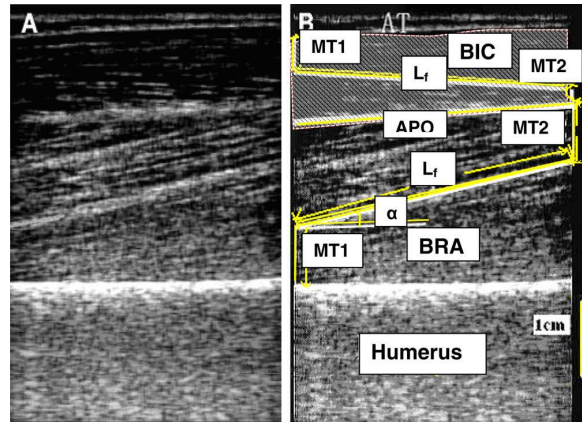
A) Original ultrasound image of the biceps and brachialis from [58]. B) Image with appropriate labels for equation 5.1. The upper shaded area (BIC) is the biceps while the lower area (BRA) is the brachialis; these two muscles are separated by an aponeurosis (APO); L_f is the visible part of the muscle fascicle that can be measured; MT_1 is the distance of the fibre distal end point to the superficial aponeurosis; MT_2 is the distance of the fibre proximal end to the bone; α is the pennation angle
